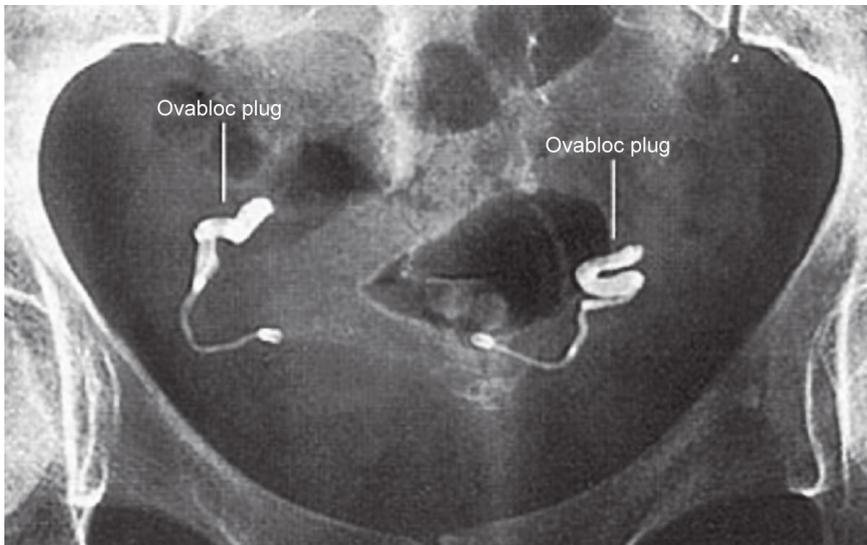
X-ray film showing an appropriate placement of Ovabloc (http://www.ovabloc.nl/ovabloc/the_treatment)
